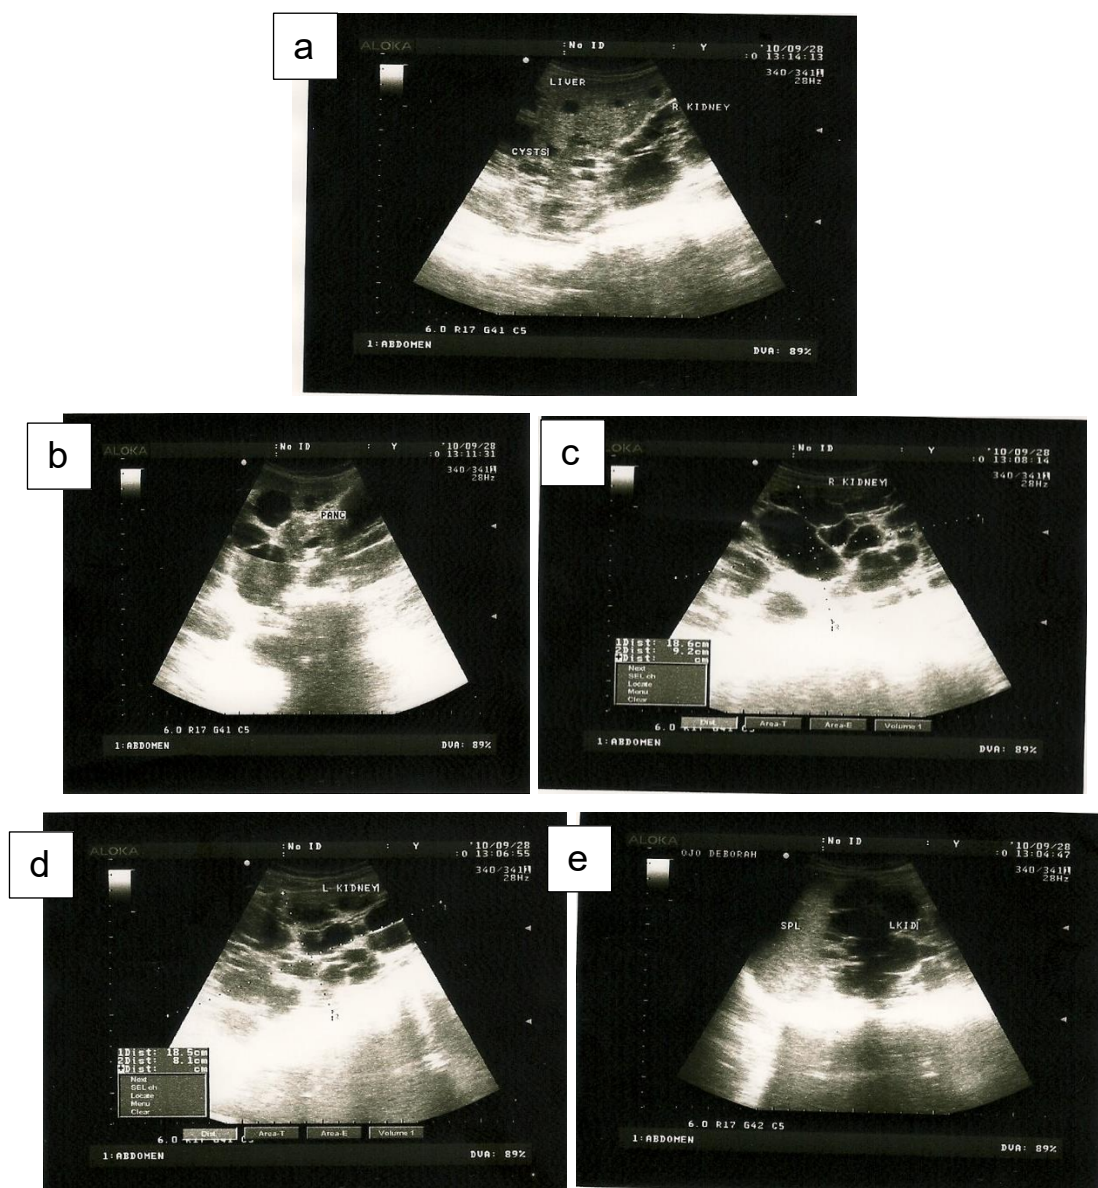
Ultrasound scan showing (a) multiple cysts in the liver and hepatomegaly, (b) ill-defined pancreas due to cystic involvement, (c) multiple cysts and renomegaly in the right kideney, (d) multiple cysts and renomegally in left kidney, and (e) spleen that was within normal limits
